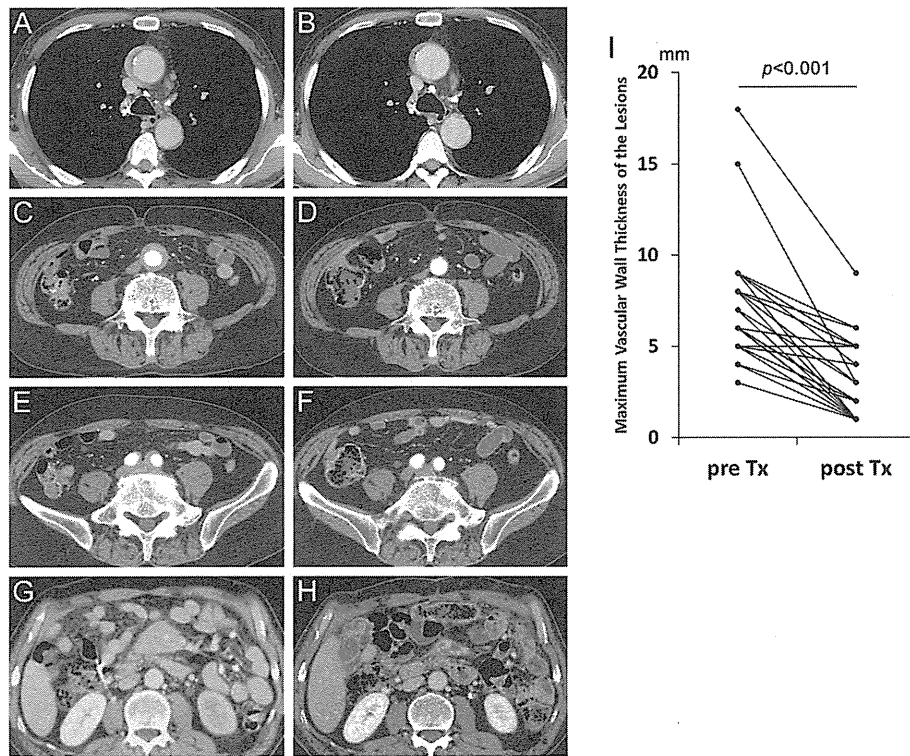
Contrast-enhanced computed tomography findings of periaortic/periarterial lesions and changes after corticosteroid therapy. A thoracic aortic lesion (A) had slightly improved 1 month after corticosteroid therapy (B), an abdominal aortic lesion (C) and an iliac arterial lesion (E) had almost disappeared 10 months after therapy (D and F, respectively) and a superior mesenteric arterial lesion (G) showed fair improvement 2 months after therapy (H). Significant pre- to posttherapy decreases in maximum wall thickness of periaortic/periarterial lesions were observed (I). Tx, Treatment.
